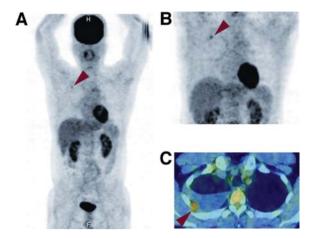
PET/CT findings of a localized MPM patient. Maximum intensity projection (MIP) PET imaging showed a faint level of abnormal FDG uptake (arrrowhead, SUVmax 2.7) in the right thorax at early phase (A) and more intense FDG uptake (SUVmax 3.0) at delayed phase (B). PET/CT showed intense FDG uptake in the right pleura with pleural effusion at delayed phase (C).
